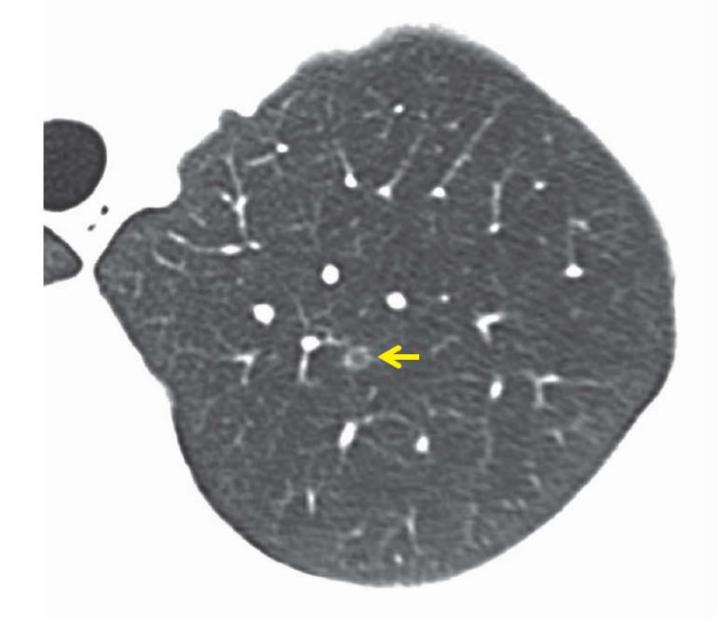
Cavitary rheumatoid nodule. CT through the left upper lobe shows a small thin-walled cavitary nodule (arrow), which resolved on follow-up. Hansell Imaging of Diseases of the Chest. 5th Ed
